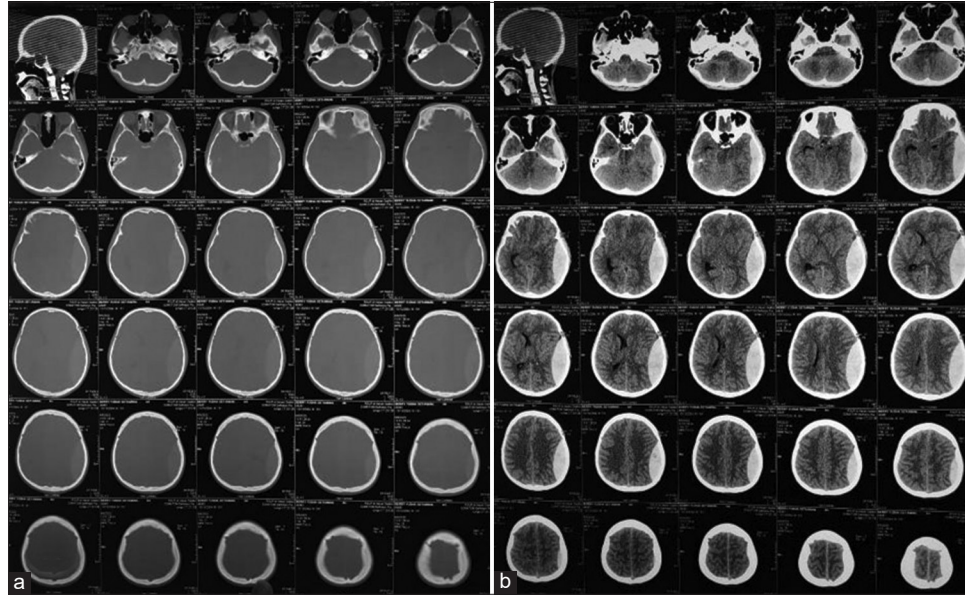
Following of the noncontrast head CT scan showed the presence soft-tissue swelling on the left temporal without bone fracture (a); compressed sulci, gyri, Sylvian fissure, and ventricles, then a massive biconvex hyperdense mass on the left temporoparietal region (± 40 cc) with midline shift >5 mm (b).
